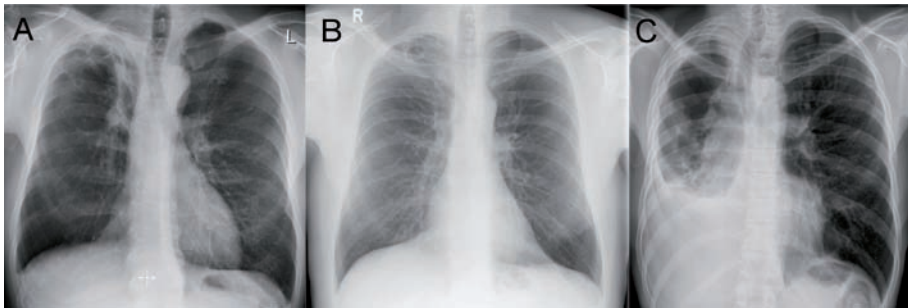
Chest radiographs of patients who underwent surgical treatment
